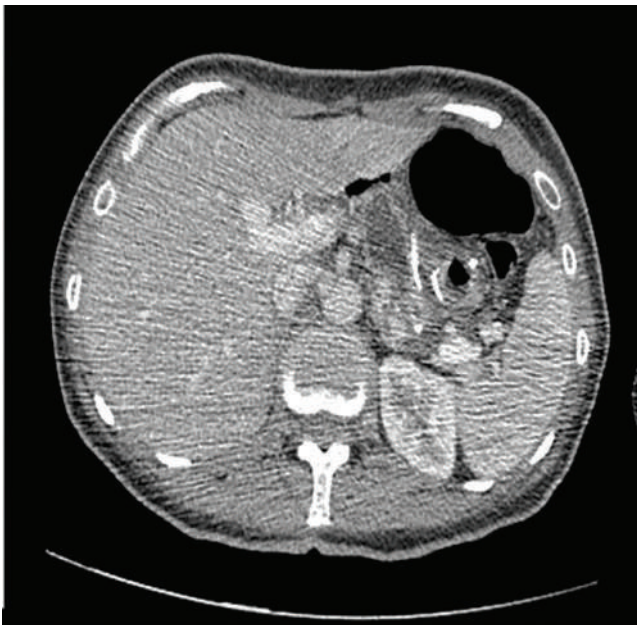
Case 1: preoperative contrast-enhanced CT image (axial). Minimal free fluid is observed in the pelvic cavity, along with metallic suture materials related to previous surgery. No obstructive pathology is identified.
